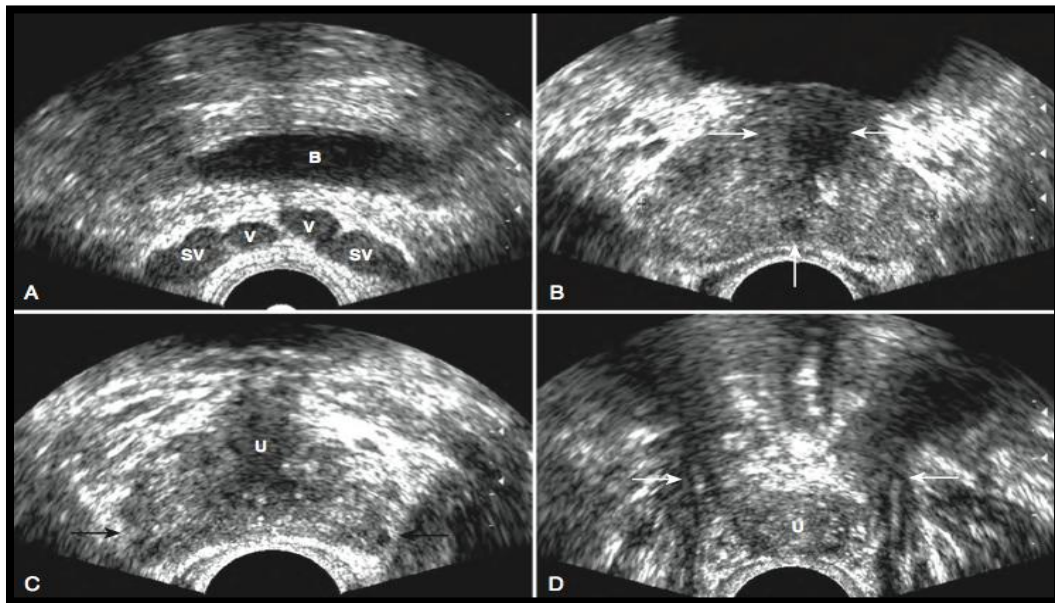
Axial Sonographic Examinations of The Prostate Gland
